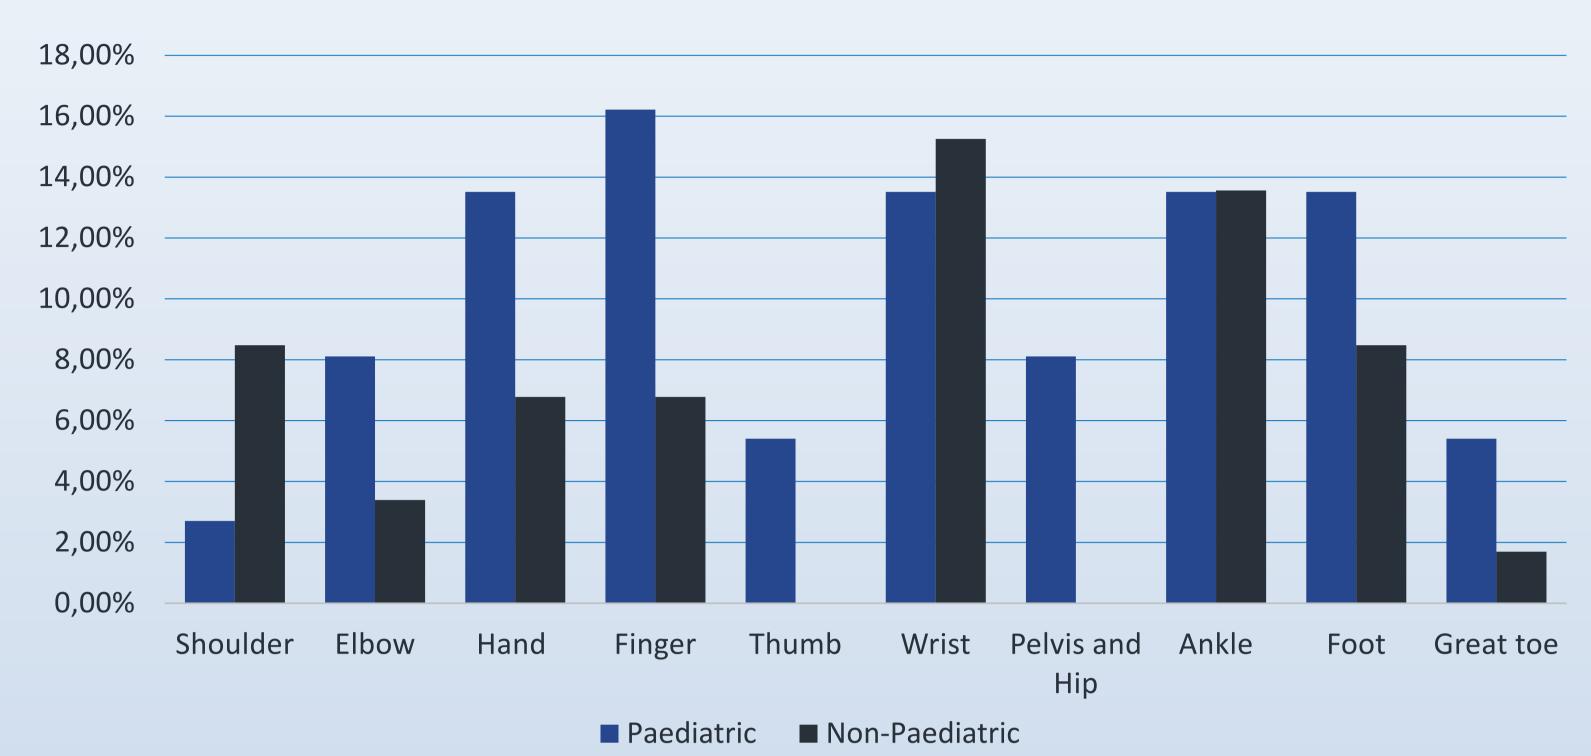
A comparison of percentage of missed findings between paediatric and non-paediatric populations by *EPIC* radiograph order option.
